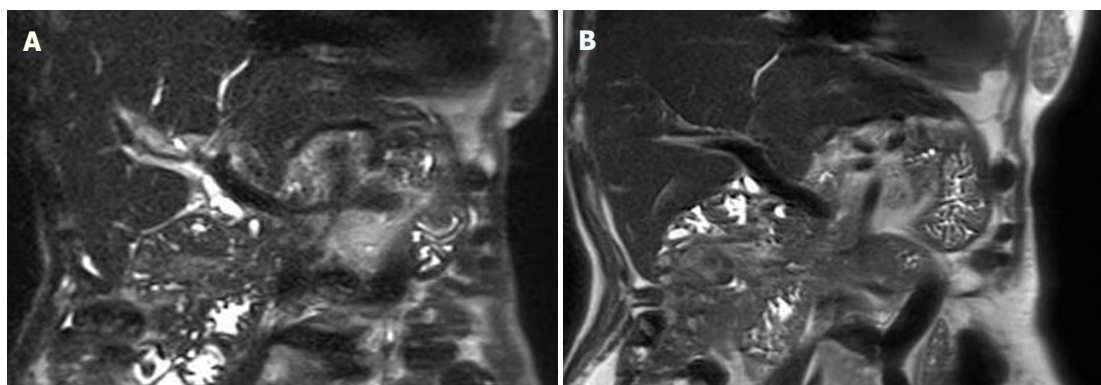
T2 magnetic resonance imaging. A: T2 magnetic resonance imaging segment VIII biliary stricture before treatment; B: T2 magnetic resonance imaging after budesonide showing resolution of segment VIII stricture.
